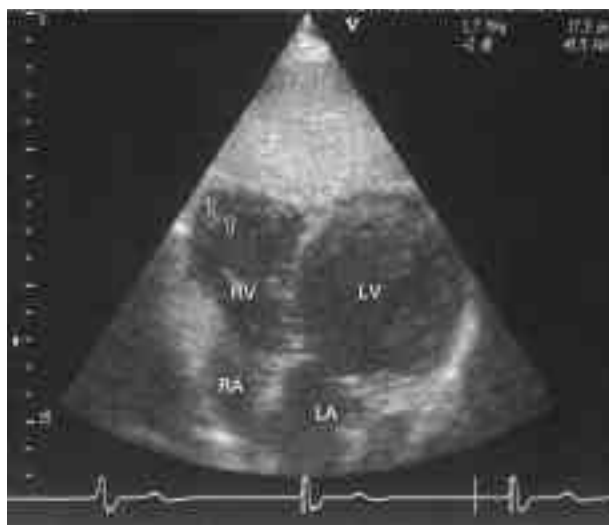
The 2-D Echocardiography seen from the sub-sternal view shows a dilated and distorted right ventricular cavity with a hyperechoic RV wall.
